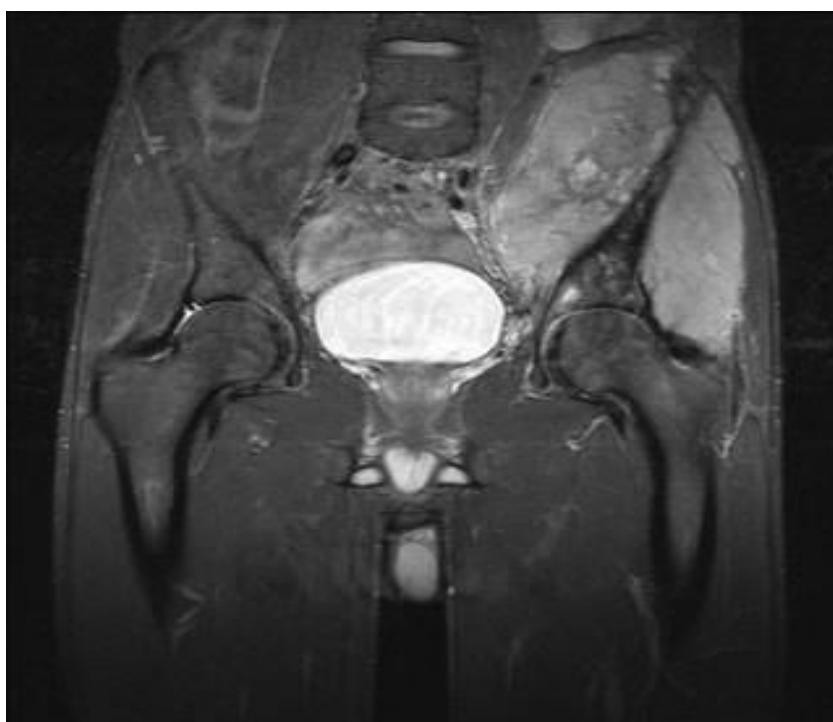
Ewing's sarcoma involving the pelvis. The plain radiograph shows a lytic mass involving the left ilium. The magnetic resonance imaging more clearly shows the massive size of the tumour with the associated large soft-tissue mass.
